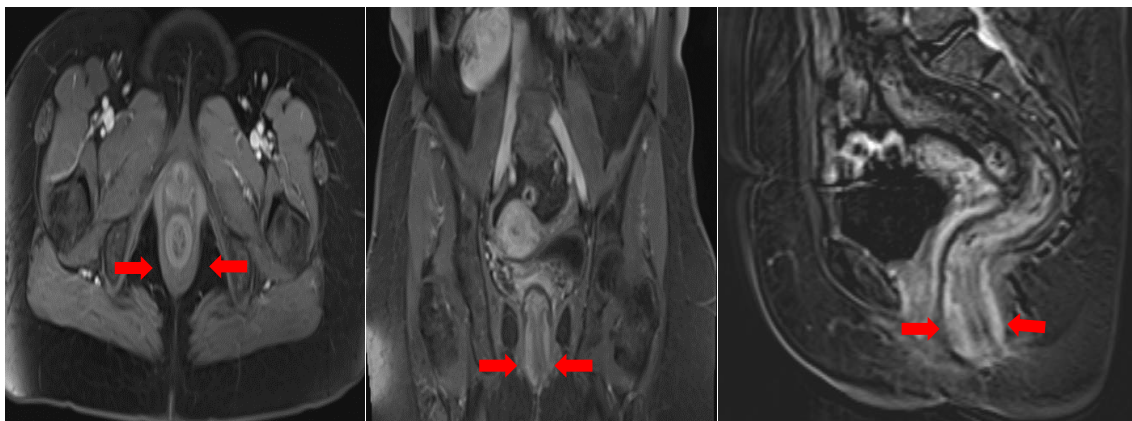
Axial and coronal sections of MRI show that the ultrastructural of the rectum and surrounding tissues are normal (blue arrows)
